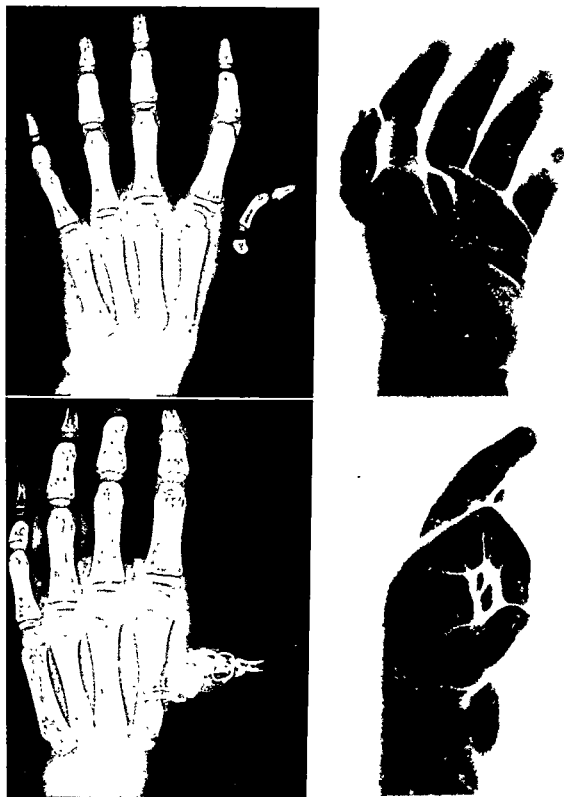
The floating thumb, a form of partial ectrodactylia. (Top, left) Roentgenogram. The thumb literally floats, since it has no metacarpal to support it. (Top, right) Its location is too far distalward, being attached at the level of the metacarpophalangeal joint rather than at the thenar eminence. The thumb has no voluntary movement but does have good sensation. At the first operation the thumb was transplanted to the thenar eminence on a neurovascular pedicle, thus preserving both vascular and nerve supply. (Bottom, left) Roentgenogram taken after the second operation, in which a free transplant of a metatarsophalangeal joint was carried out. Growth has continued thus far (3 years). (Bottom, right) The child pinching after tendon transplantation for flexion and extension.
